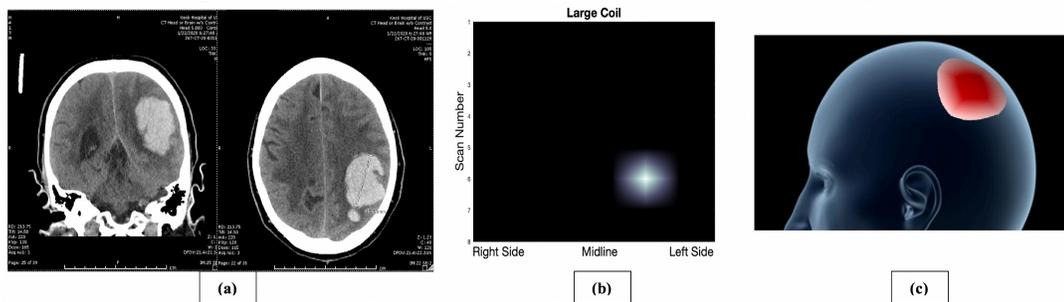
a) CT imaging showing a left parietal lobar ICH b) Two-dimensional data gathered from ECD sensor scanning. c) Three-dimensional projections of the lesion.
